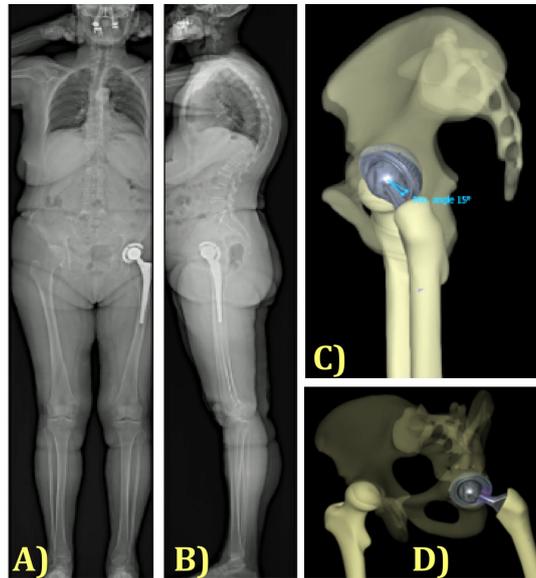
Standing EOS-radiographs with 3D-reconstructions showing 28 mm THA with anterior subluxation (left-hip, female patient): (A) EOS anterior view; (B) EOS lateral view; (C) femoral-neck on cup rim in lateral view; (D) Oblique view of femoral-neck impinging cup rim.
